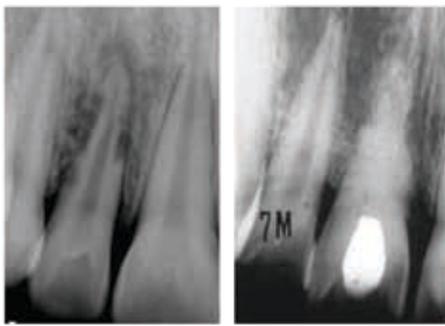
(Left) Periapical radiograph of tooth with external inflammatory root resorption showing radiolucent areas on the root and the alveolar bone. (Right) Periapical radiograph of tooth #8 with replacement resorption. The periodontal ligament space is not visible, and the root has been partially resorbed. (Images courtesy of Dr. Frederic Barnett.)
